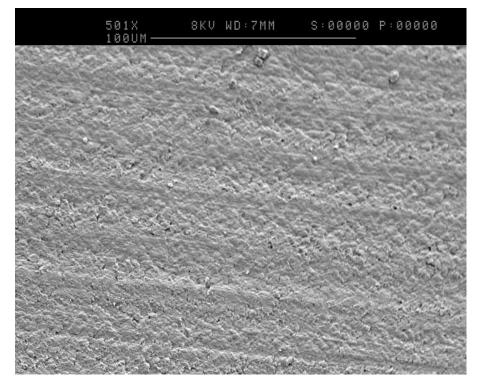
SEM image (500x magnification) to show image from pilot study with ultrasonication with 5% SDS without mechanical brushing (Hülsmann score 4).
